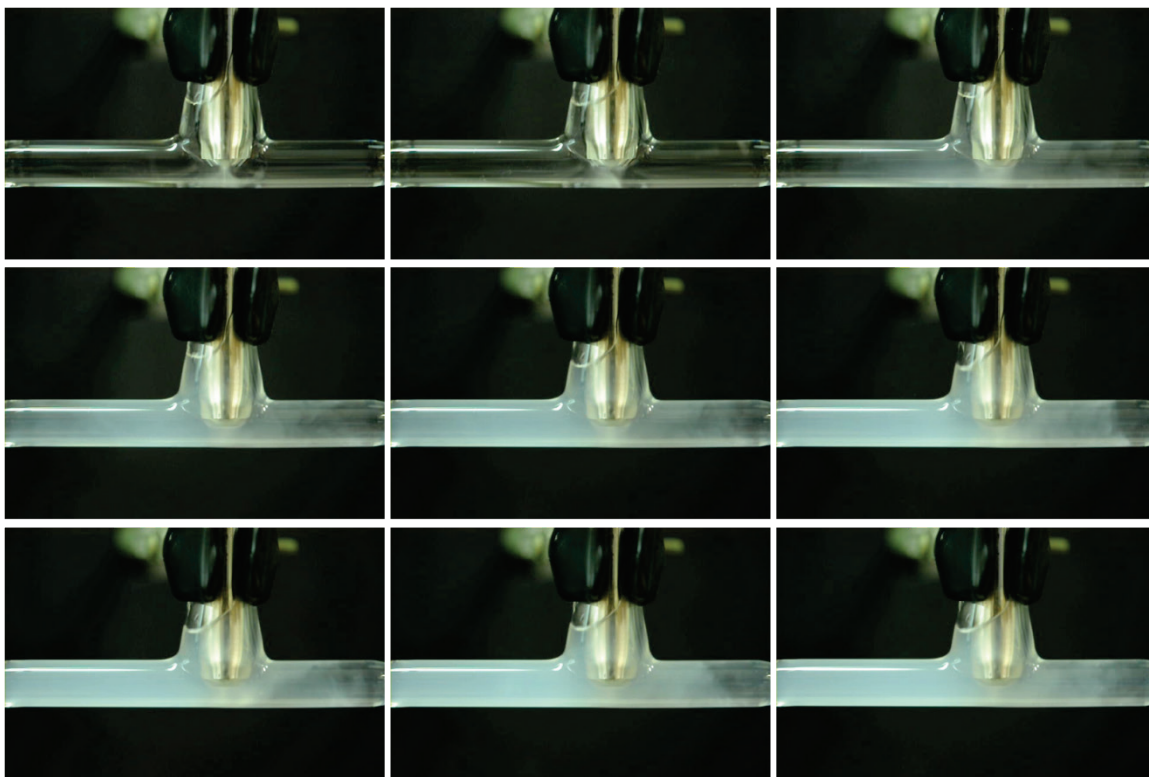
Spray sonocrystallization. Antisolvent sonocrystallization of aspirin. A saturated solution of aspirin in ethanol is ultrasonically dispersed in a continuous flow of water (flowing right to left). Images are extracted from a video, each frame is separated by 3 seconds. In the first two frames the horn is on but no solvent has reached the antisolvent yet; the slight cloudiness is solely from cavitating bubbles. Crystallization begins in the third frame.
